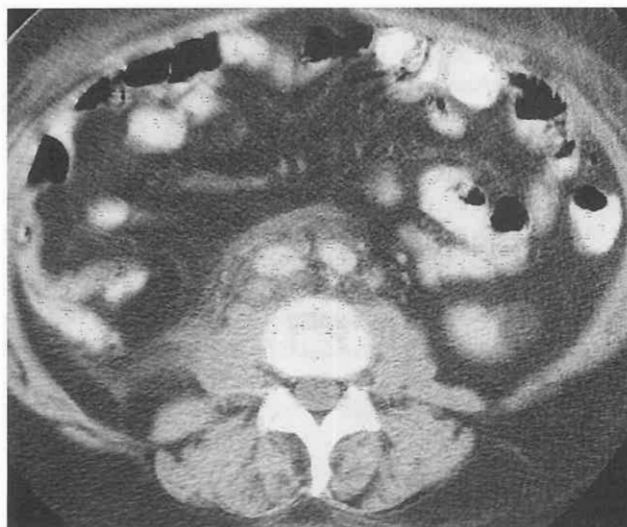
Treated non-Hodgkin lymphoma. Contrast-enhanced CT scan demonstrates residual soft tissue in the para-aortic and paracaval regions of the retroperitoneum in a patient who has undergone chemotherapy. The poorly defined soft tissue stranding is frequently identified in patients with treated lymphoma. Although all of the remaining tissue might represent fibrosis, the possibility of residual viable tumor cannot be excluded. In this patient, the soft tissue remained stable on scans over several years, suggesting that no residual tumor was present.
